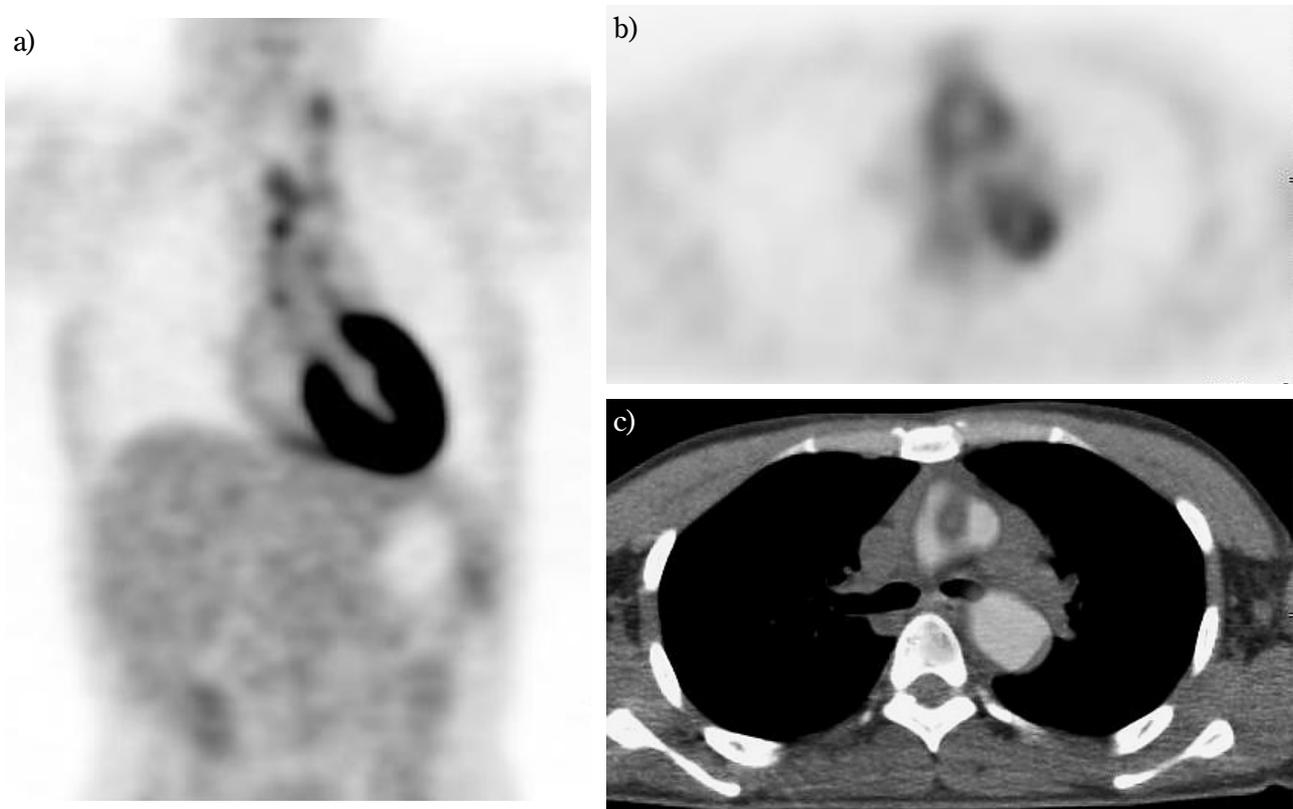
A 32-year-old female. a) Coronal view of FDG-PET. b) Axial view of FDG-PET. c) Axial view of PET/CT image. FDG-PET/CT shows increased FDG uptake in the thoracic aorta and its branches (brachiocephalic artery and carotid arteries)
